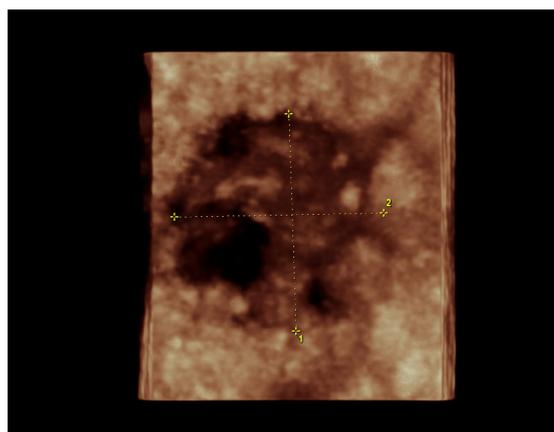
The reconstructed coronal plane with 3D ultrasound shows the heterogeneous mass with irregular and speculated margins.
